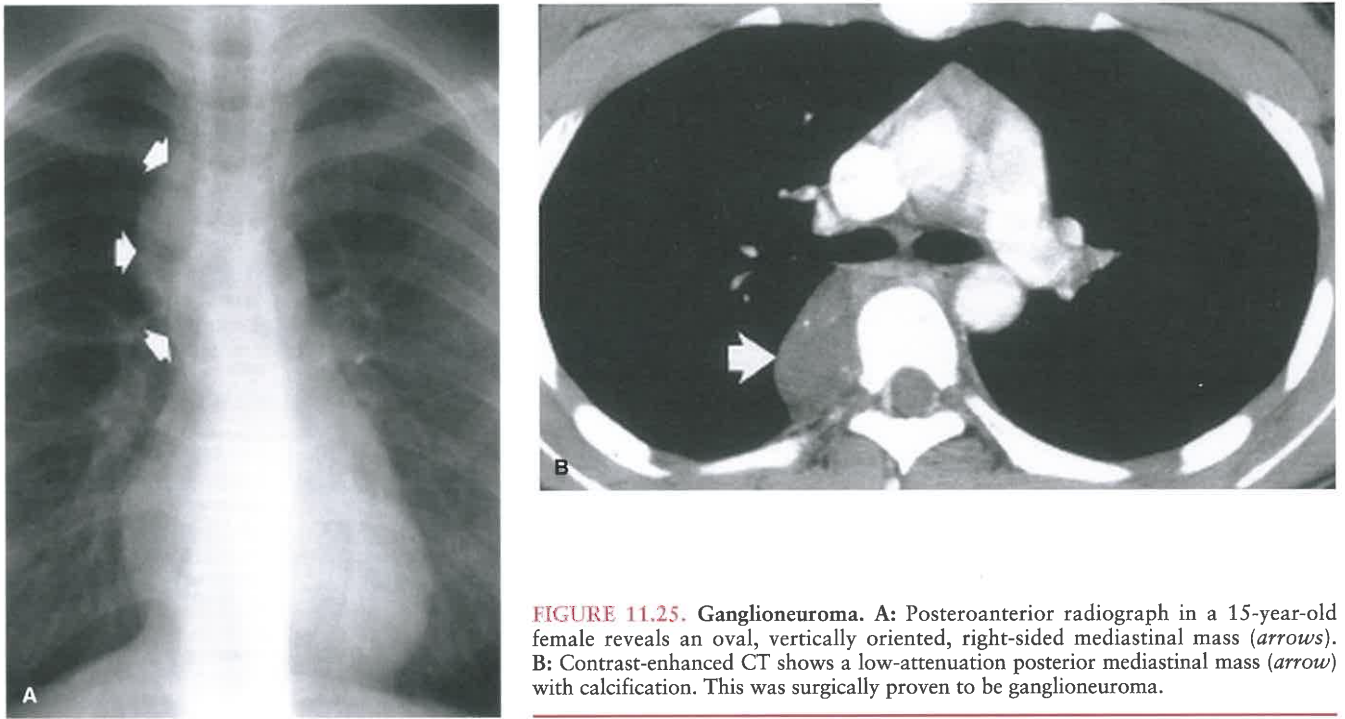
Ganglioneuroma. A: Posteroanterior radiograph in a 15-year-old female reveals an oval, vertically oriented, right-sided mediastinal mass (*arrows*). B: Contrast-enhanced CT shows a low-attenuation posterior mediastinal mass (*arrow*) with calcification. This was surgically proven to be ganglioneuroma.
